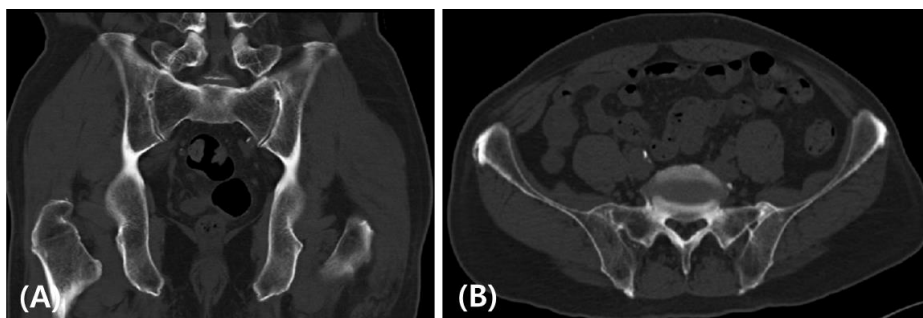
Computed tomographic images show evidence of partial ankylosis of bilateral sacroiliac joints. (A) coronal image and (B) axial image
